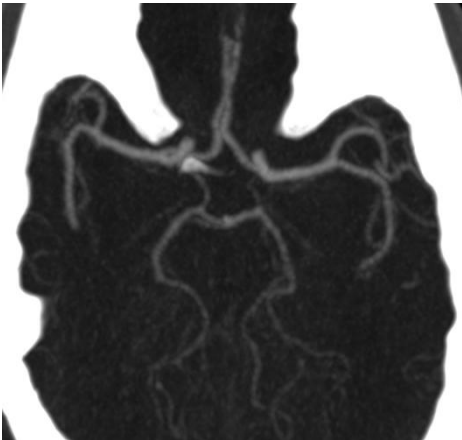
Axial cerebral CTA MIP image showing a complete CW configuration*
